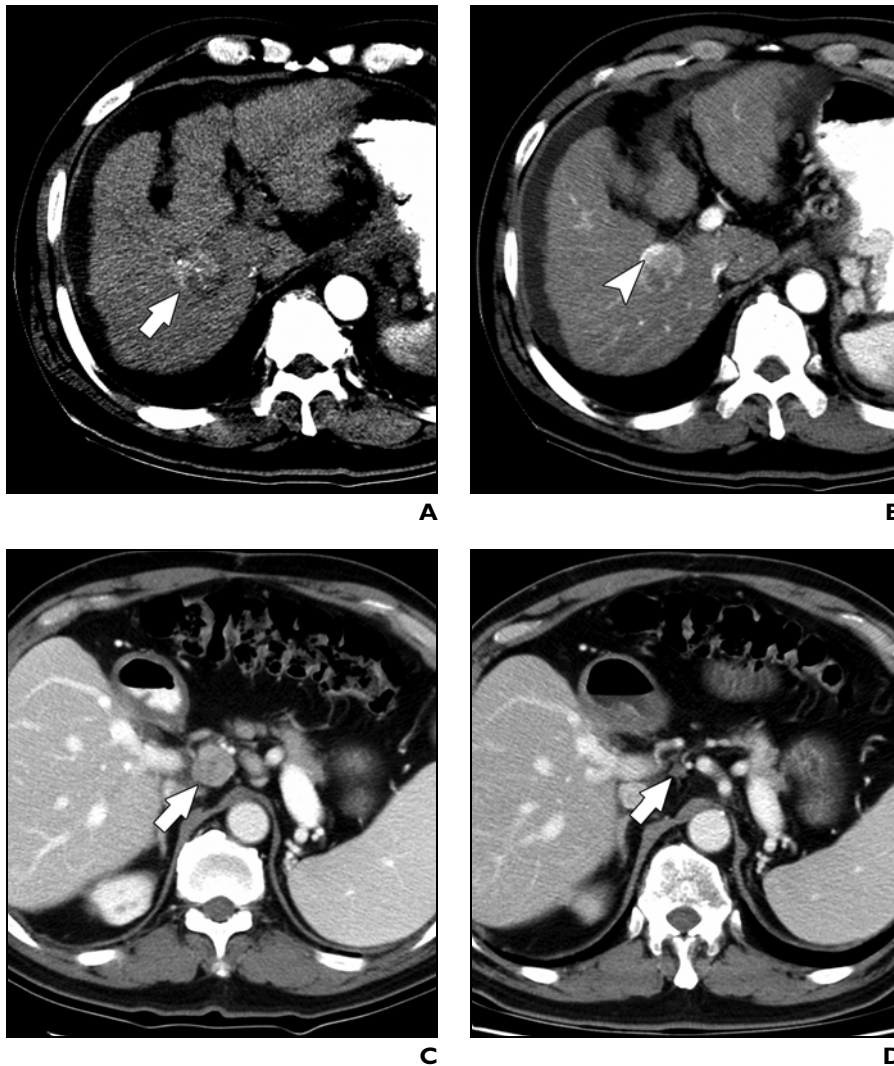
53-year-old man with stable disease after radiation therapy for recurrent hepatocellular carcinoma after liver transplantation and with hepatitis B–related liver cirrhosis in Child-Pugh class B. A and B, Contrast-enhanced CT scans show 3-cm hepatocellular carcinoma (*arrow*, A) in right hepatic lobe with right intrahepatic portal vein invasion (*arrowhead*, B) managed with living-donor liver transplantation. C, Contrast-enhanced CT scan shows solitary recurrent tumor found in celiac lymph node (*arrow*) approximately 22 months after liver transplantation. D, Contrast-enhanced CT scan after radiation therapy shows considerable decrease in size of celiac lymph node (*arrow*). Patient survived in stable condition for 48.9 months after transplantation.
